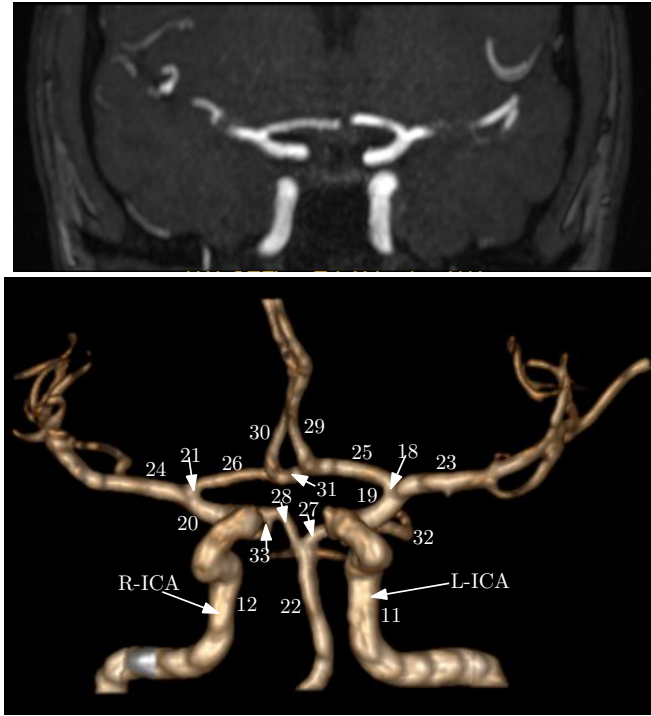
A TOF MRI scan (top) and the resulting segmented 3D model of the complete circle of Willis (bottom) for patient-specific case. The numbers on segmented model correspond to the ID's of the arterial segments in Table 5.3.
